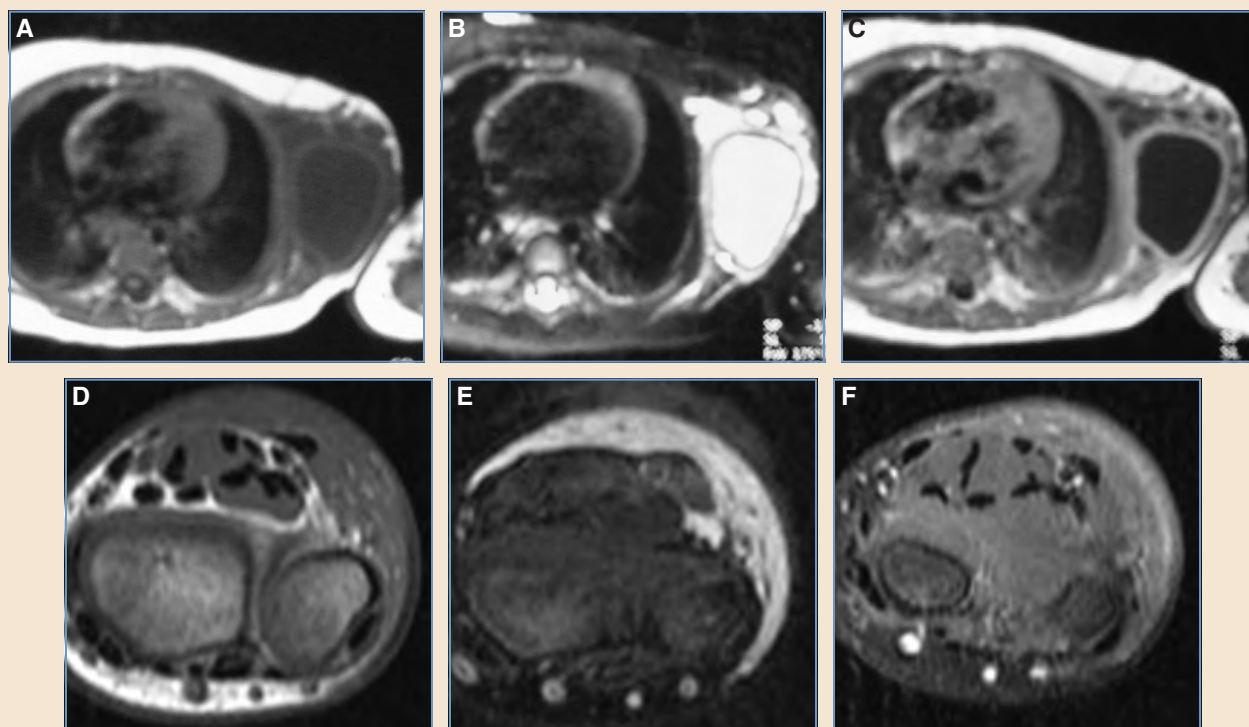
Typical MRI features of cystic lymphatic malformation. A-C, Macrocystic chest wall lymphatic malformation. D-F, Microcystic lymphatic malformation of the forearm in the same patient shown in Fig. 13-6, *B* and Fig. 13-20, *E*. B, Both macrocystic and microcystic lymphatic malformations have similar T1 (A and D) and T2 (B and E) signal intensity (isointense on T1, hyperintense on T2). IV contrast can differentiate macrocystic from microcystic lymphatic malformation. C, Cyst rim enhancement occurs in macrocystic lymphatic malformation. F, Microcystic lymphatic malformation sometimes shows a faint diffuse enhancement throughout the lesion.
